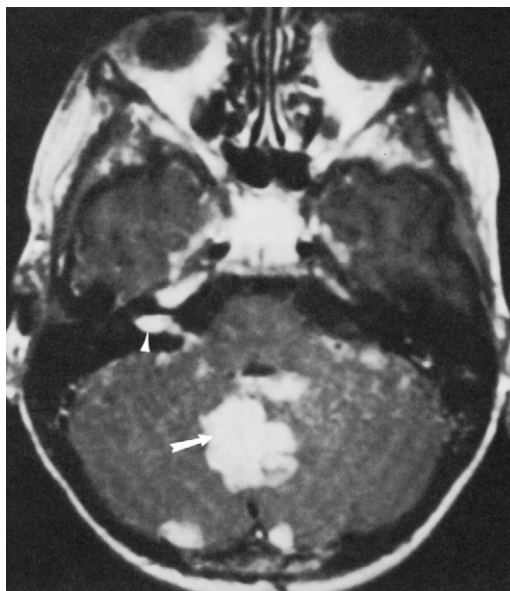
Subarachnoid metastases from primitive neuroectodermal tumor. Axial postcontrast magnetic resonance images (SE 500/20). There is an enhancing mass in the cerebellar vermis (*arrow*). There are multiple subarachnoid metastases including one in the right internal auditory canal (*arrowhead*).
